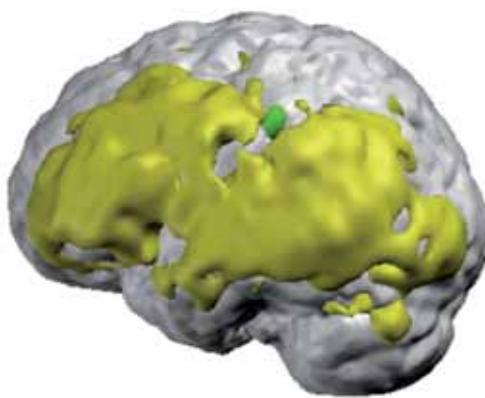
Co-registration of PET, subtraction ictal SPECT (SIS-COM) and MRI: 50 year-old patient with partial motor seizures. The MRI revealed a discrete left parietal abnormality suggestive of dysplasia. PET (yellow) and SISCOM (green) co-registered with the MRI showed a focal interictal hypometabolism and ictal hyperperfusion that was concordant with the MRI abnormality.
